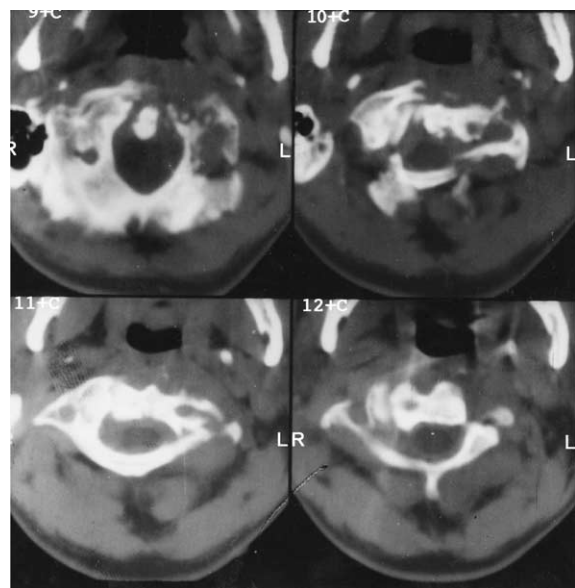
Axial CT scan of CVJ showing extensive destruction of anterior arch of atlas, dens, and part of axis correlating with Lifeso stage III CVJ tuberculosis.
